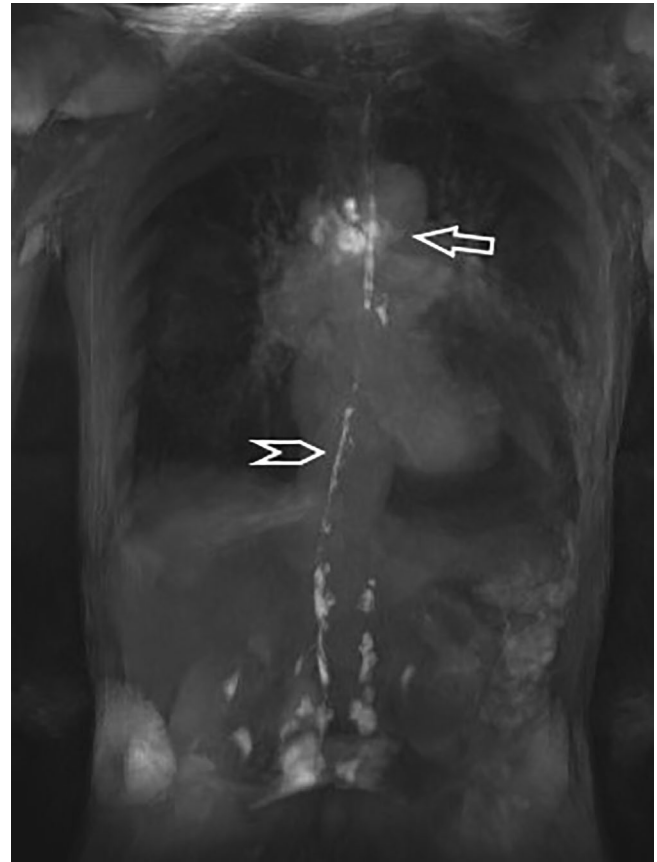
Dynamic contrast-enhanced magnetic resonance lymphangiography demonstrating a central lymphatic flow disorder. Coronal maximum intensity projection (MIP) of T1-weighted sequences post intranodal contrast shows leakage into pericardial fluid (arrow) from the thoracic duct (arrowhead)
